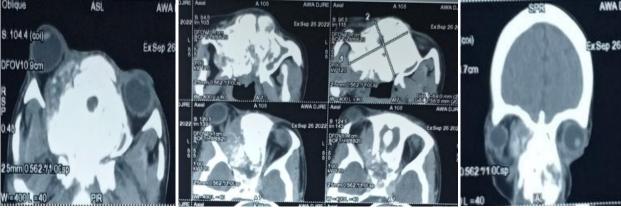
Maxillofacial CT in axial and coronal section
